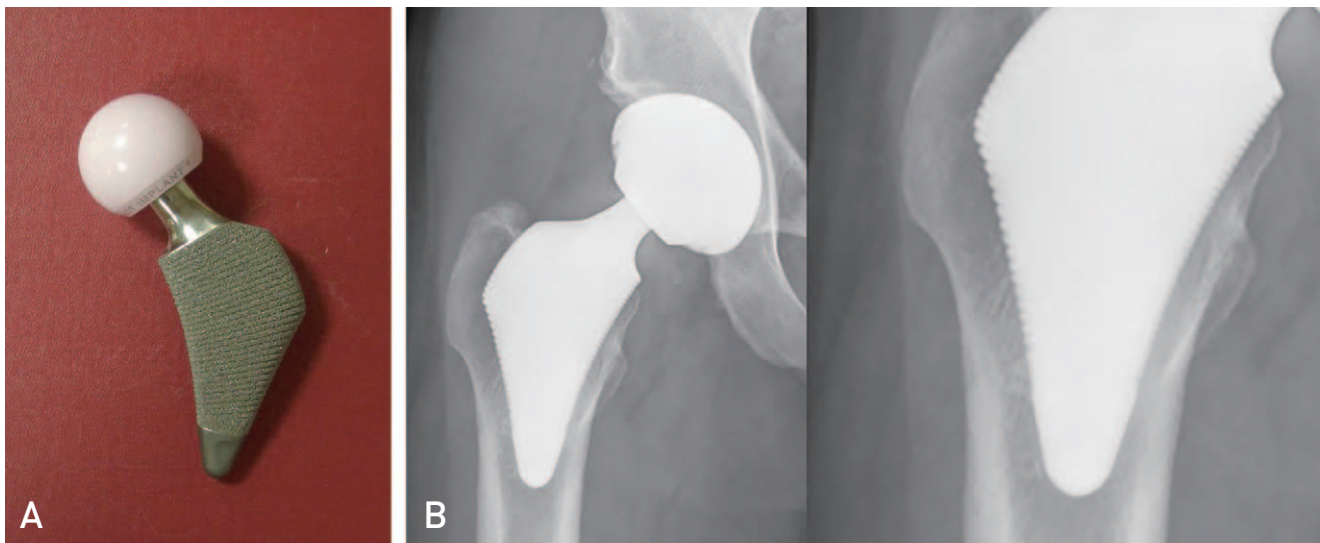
(A, B) Photo of a Proxima (DePuy) stem and a radiograph of the right hip taken 15 years after the operation.
